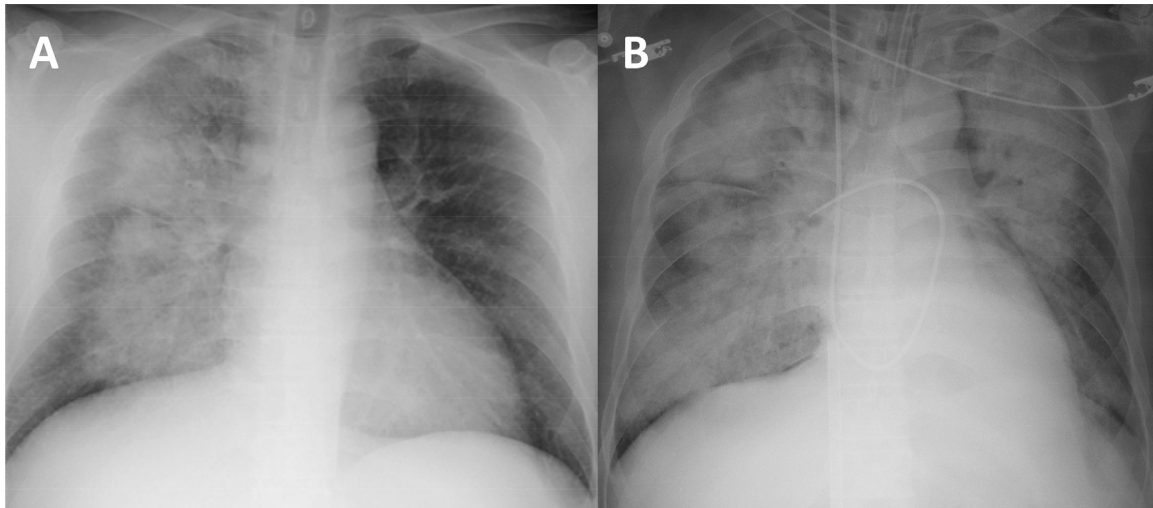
(A) Chest radiograph on admission at the district hospital showing unilateral consolidation of the right lung field. (B) Chest radiograph at transfer six days later showing bilateral severe consolidation resembling “butterfly shadow”.
